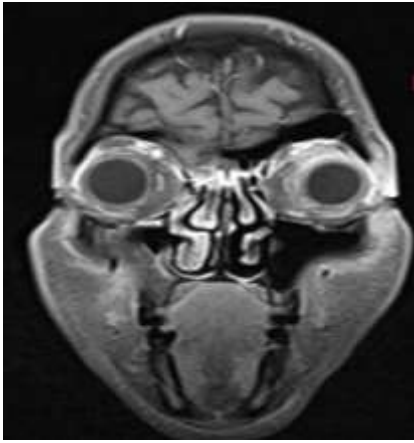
MRI orbit shows periorbitalpreseptal enhancing soft tissue swelling bilaterally with more prominent on the left side consistent with orbital cellulitis
